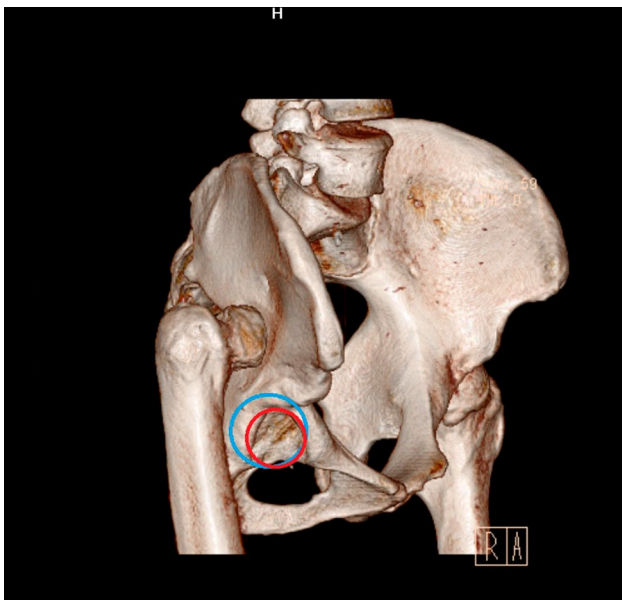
Oblique pelvis 3D pelvis CT. Red line shows the place of acetabular cup in standard technique (true acetabulum). Blue line shows the place of acetabular cup in described technique (the area between ischium and SIAI)
